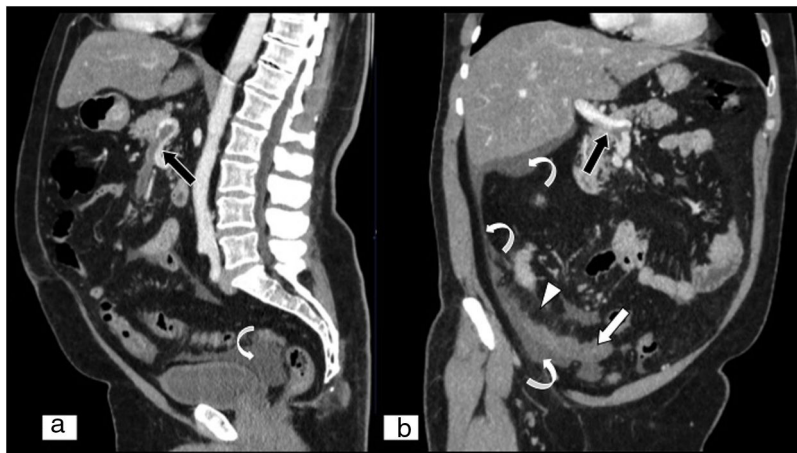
Mesenteric ischaemia of venous origin. (A) MPR on a sagittal plane in an abdominal and pelvic computed tomography (CT) scan. (B) MPR on an oblique coronal plane in an abdominal and pelvic CT scan, both with iodinated intravenous contrast in a portal phase. Filling defect of the superior mesenteric vein extending towards the proximal end of the portal vein (black arrows). Loops of small intestine with decreased parietal uptake (white arrow), engorgement of mesenteric vessels and increased density or striation of fat due to oedema are seen (white arrow tip). Free fluid is also seen in the right paracolic gutter, perihepatic space and pelvis (curved white arrow).
